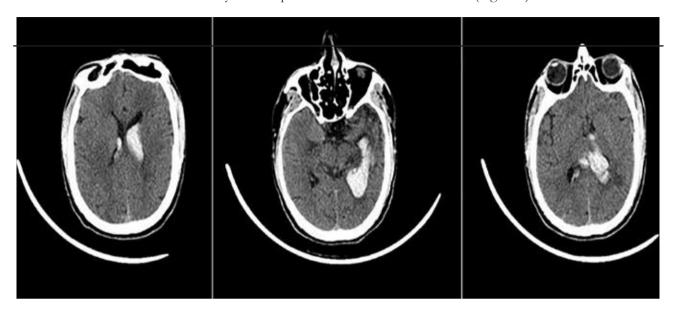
CT scan showing presence of bleed in the lateral ventricle – body, temporal horn and atria
